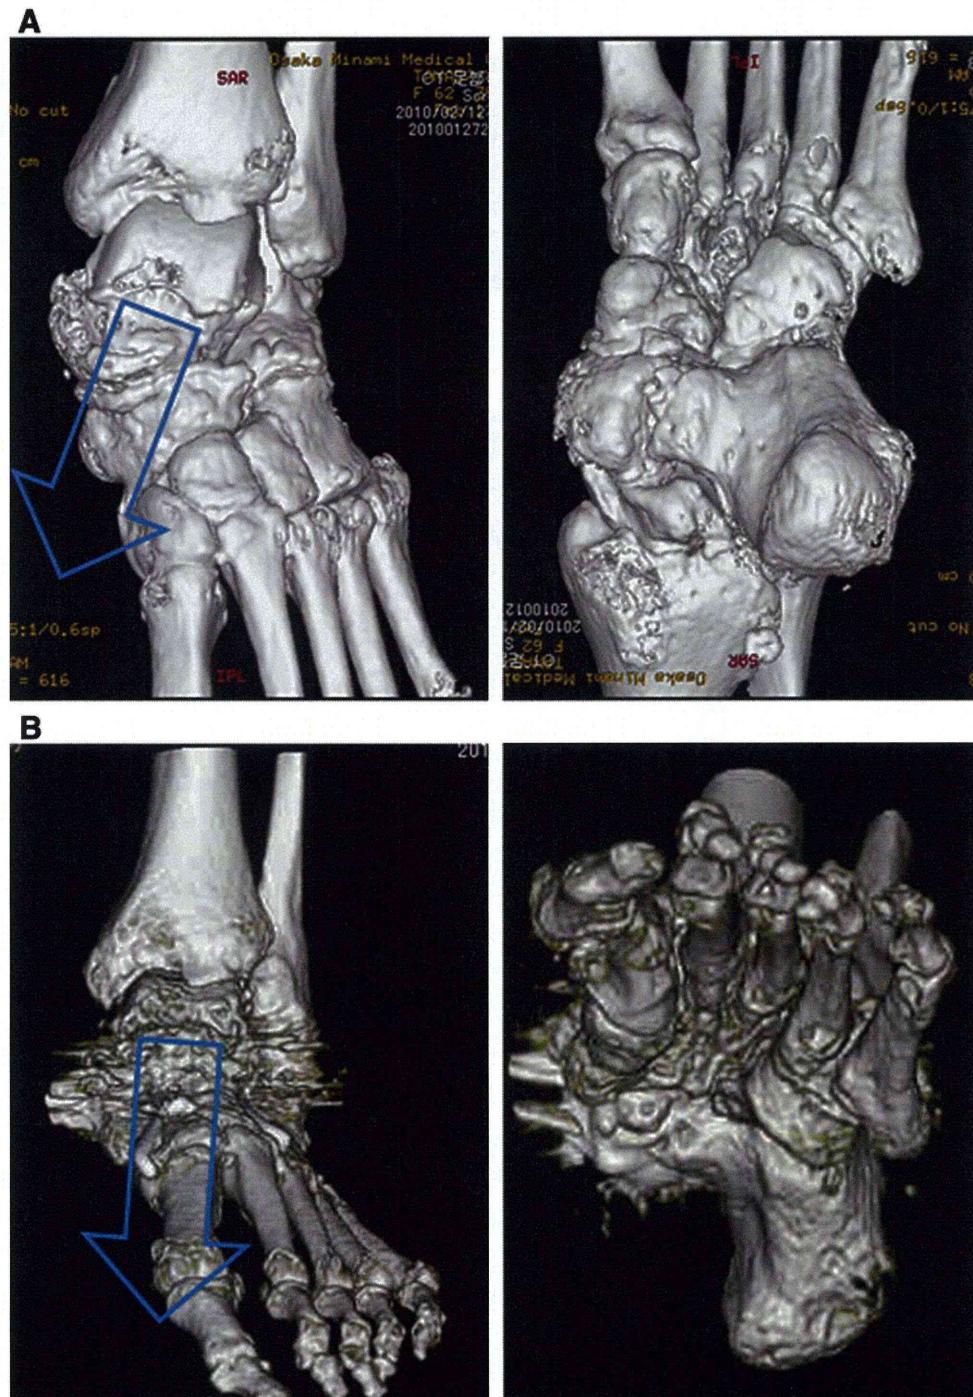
Preoperative (a) and postoperative (b) images from three-dimensional computed tomography (3DCT). Preoperatively, dislocation of the talus bone from the talonavicular joint was confirmed, suggesting a severely pronated foot (*blue arrow in a*), while reduction
